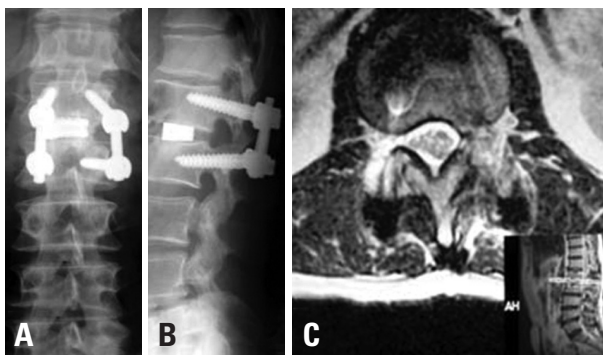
Postoperative X-P (A: anterior-posterior, B: lateral) showing good sagittal alignment. Postoperative MRI (C), showing sufficient decompression of the dural tube.
